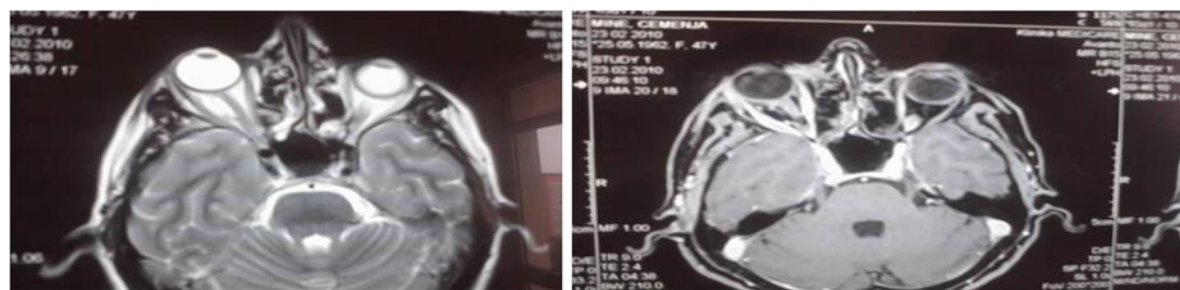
Orbit MRI reveals enlargement of lateral recti muscles of the right eye.
